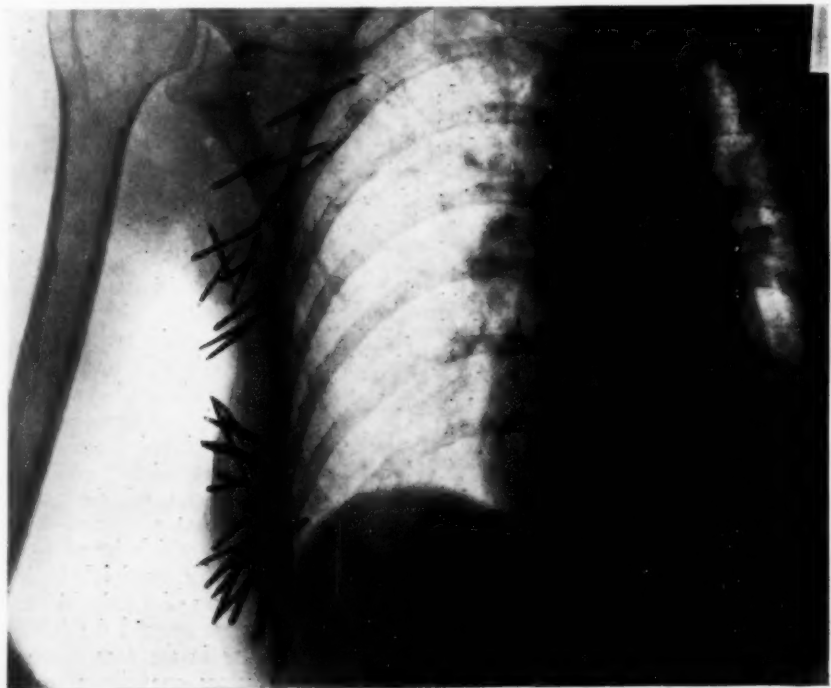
Roentgenogram of Figure V., showing the needles imbedded throughout the breast and surrounding tissues.
